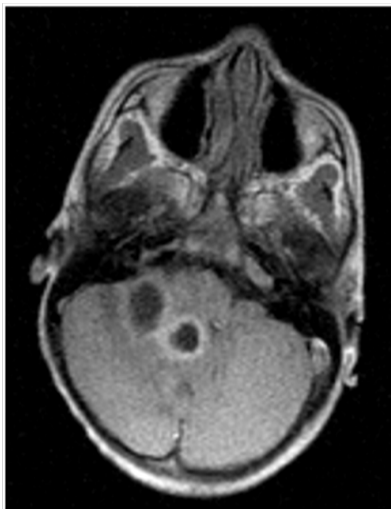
MRI showing multiple cerebellar abscesses.
